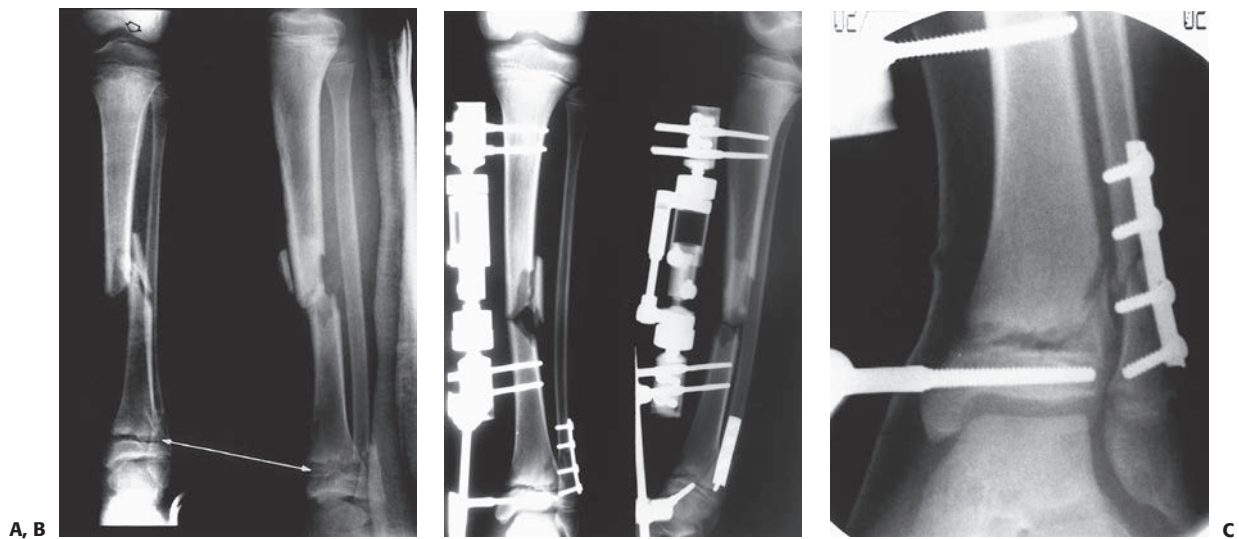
A: Anteroposterior and lateral radiographs of the tibia of a 12-year-old boy who was struck by a car. This child sustained a grade III B open middle one-third tibial fracture, a Salter-Harris type II fracture of the distal tibial physis with associated distal fibular fracture (*closed arrows*), and a tibial eminence fracture (*open arrow*). B: Irrigation and débridement and application of an external fixation device were performed. C: The fracture of distal tibial physis was stabilized with a supplemental pin attached to the external fixation device. Open reduction and internal fixation of the fibula was performed to enhance the stability of the external fixator in the distal tibia. D: Anteroposterior and lateral radiographs of the tibia approximately 9 months after injury demonstrate healing of the tibial eminence fracture, the comminuted middle one-third tibial fracture, and the distal tibial physeal fracture. The distal tibial physis remains open at this time.
